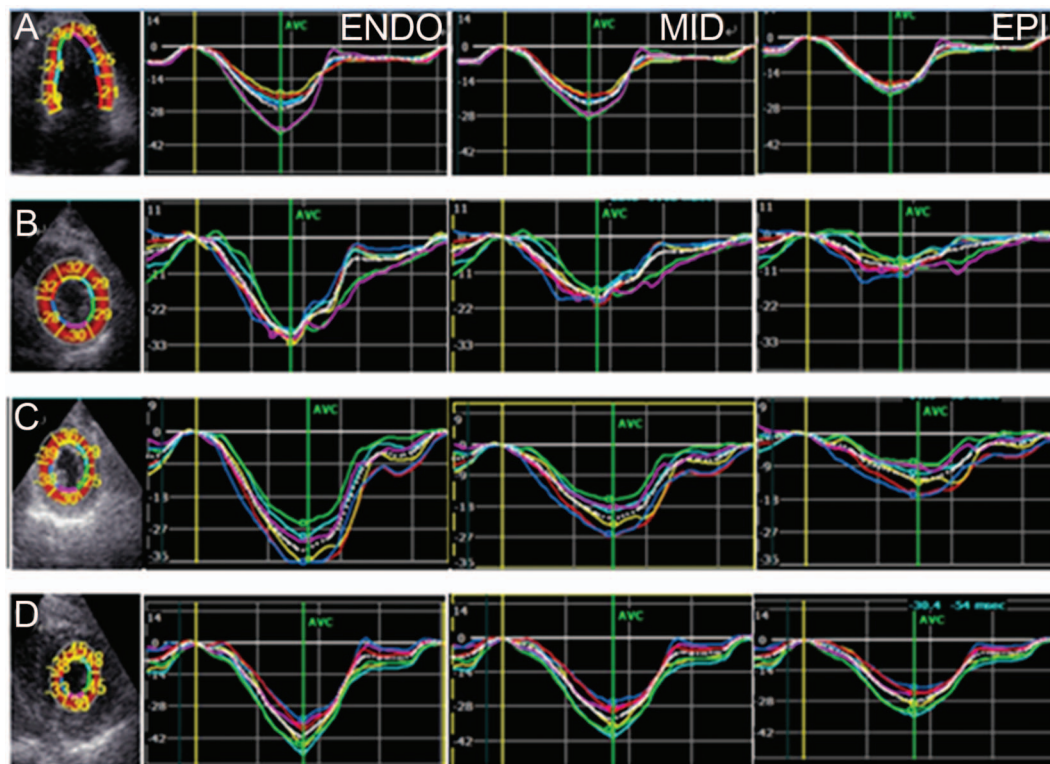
Three-layer longitudinal and circumferential strain in a control subject. Shown are an apical 4-chamber view (A), short-axis view at the level of the mitral valve (B), short-axis view at the level of the papillary muscles (C), and short-axis view at the level of the apex (D). In the apical 4-chamber view (longitudinal strain) and short-axis views (circumferential strain), endocardial strain is highest, and epicardial strain is lowest (an epicardial-to-endocardial gradient). ENDO = endocardial strain; MID = mid-layer; EPI = epicardial strain.
